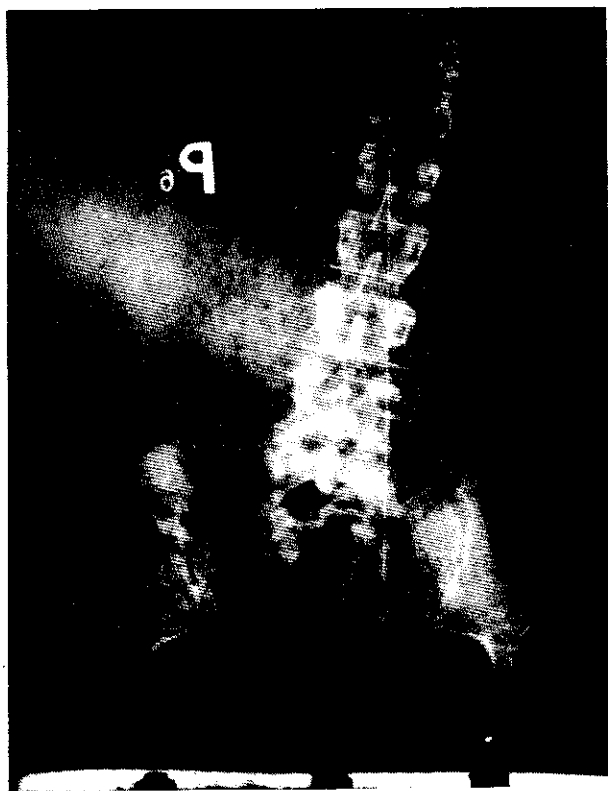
X-ray. Deviation of the lumbar spine to the left (without scoliosis) causing static strain.
